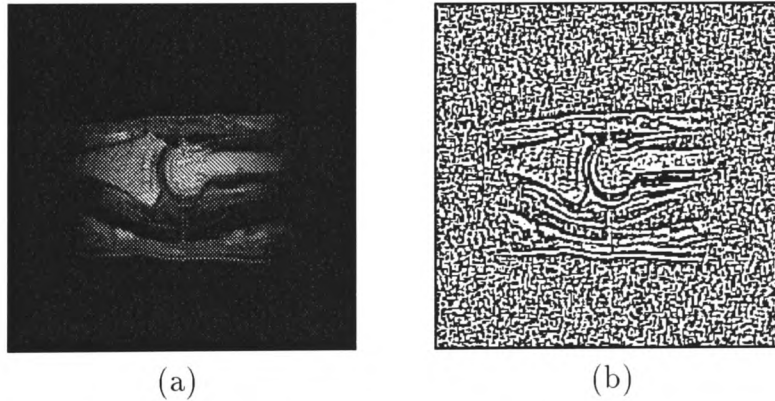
(a) MRI finger scan (b) zero crossings of image showing clear boundaries.
